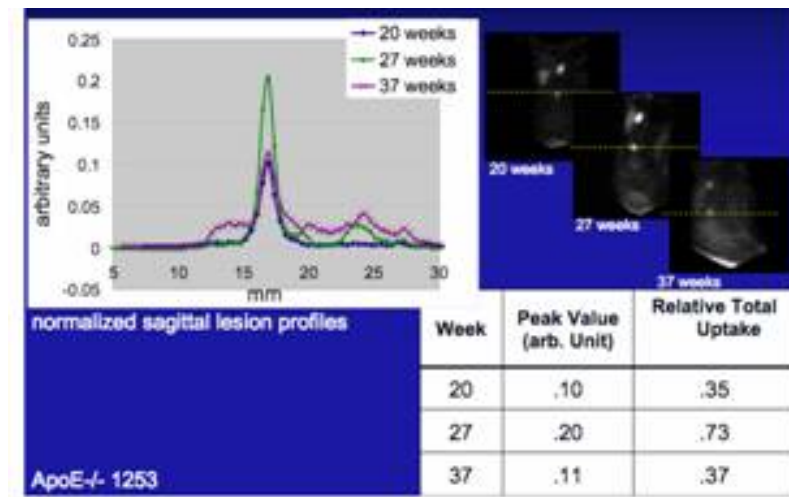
Horizontal profiles across the same focal uptake in the aorta region in the coronal SPECT images obtained at 20, 27 and 37 week as shown in Figure 1. The profiles are normalized to the same unit injected dose of ^{99m}Tc. They indicate an increase of ^{99m}Tc from 20 to 27 weeks followed by a decrease to 37 week and undetectable at 40 week
